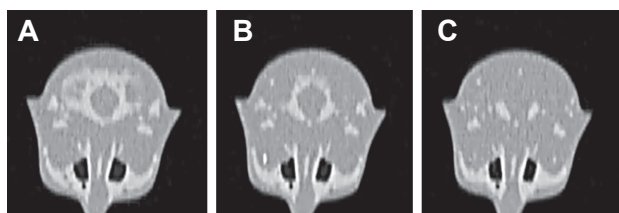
Coronal CT slices taken at level -1.8 cm (A), -2.0 cm (B) and -2.3 cm (C).
